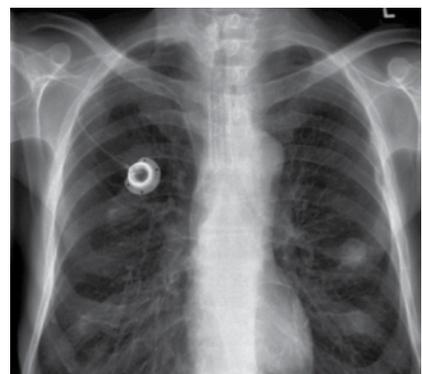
X-ray showing an implanted port¹²
